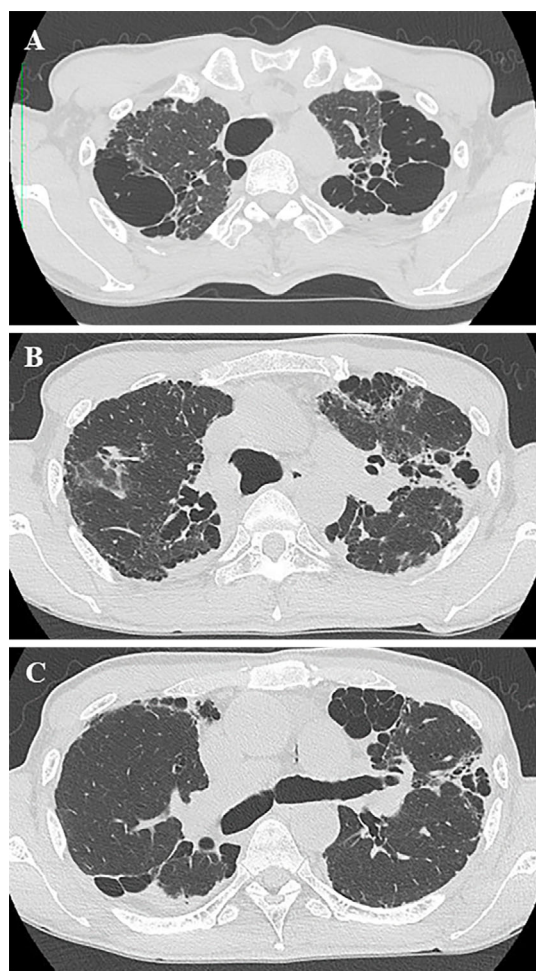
(A-C) Axial chest computed tomography images show subpleural consolidation with traction bronchiectasis and bilateral apical cysts.
